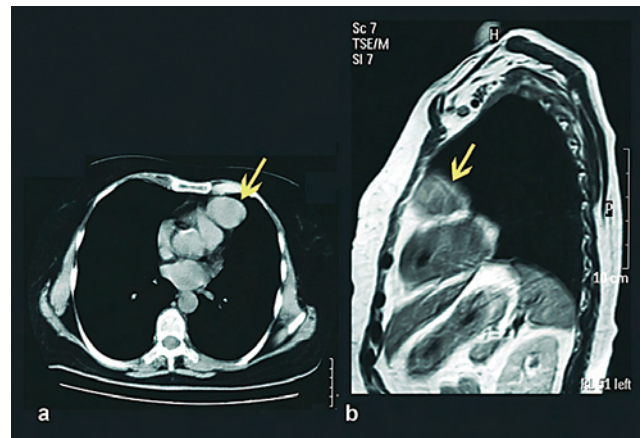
Computed tomography (a) and magnetic resonance imaging (b) revealed a solid mass located in the left lower anterior mediastinal area, in contact but not infiltrating pericardium, while signs of pressing the left lung were also noticed (arrows). Thymoma was the possible diagnosis.
